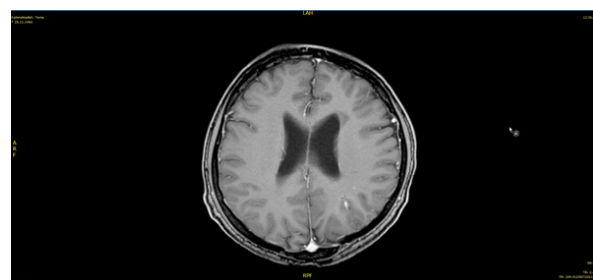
Juxtacortical demyelinating lesions (MRI-June 12, 2019).
